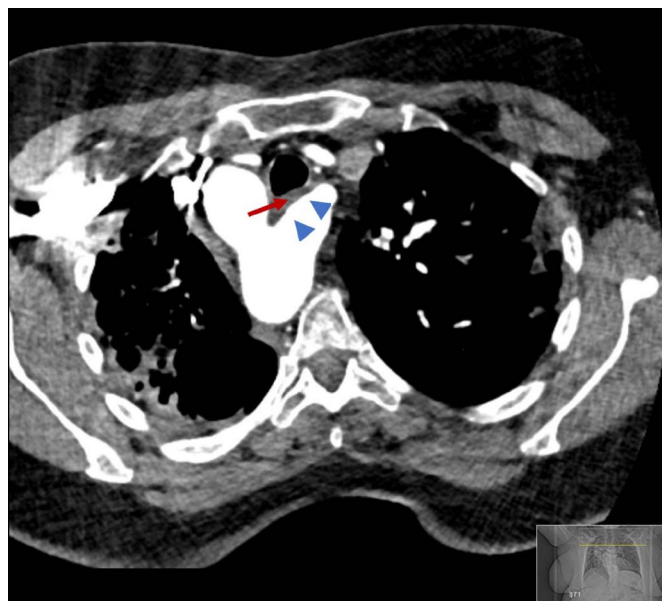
Computed tomography showing an aberrant right subclavian artery on the left aorta (blue arrows) and a Kommerell diverticulum, resulting in esophageal compression (red arrow).
